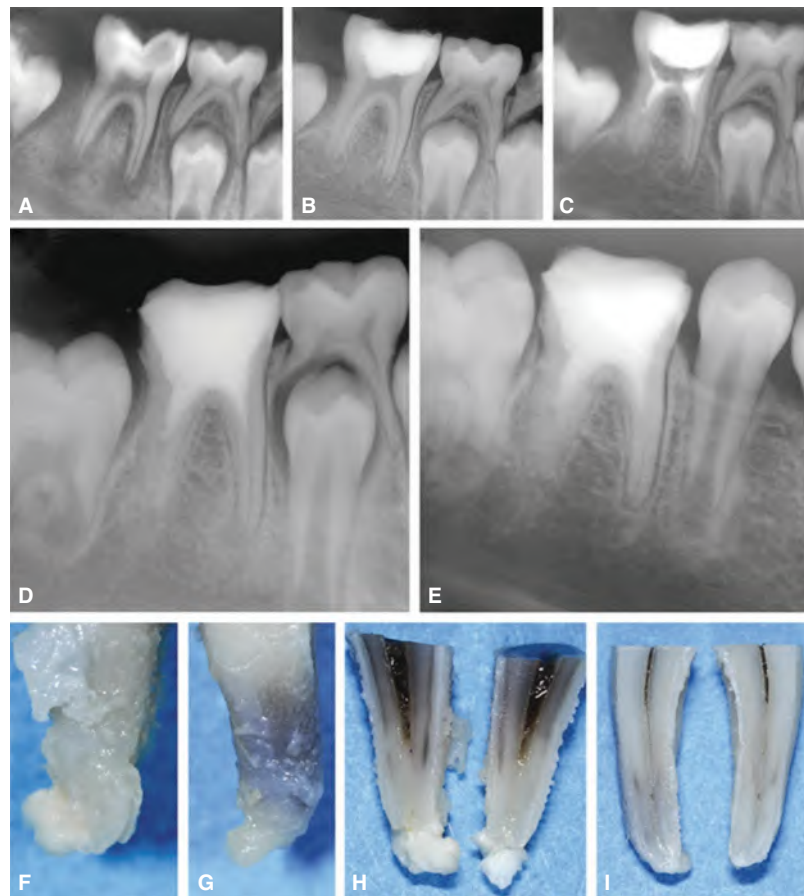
Mandibular first molar of a 9-year-old boy treated with a revascularization/revitalization procedure. A. Preoperative radiograph. B. Radiograph of the tooth taken five months after triple antibiotic treatment. C. Postoperative radiograph after revascularization/revitalization. D. 14-month follow-up radiograph. E. Radiograph taken after 25 months at the time of root fracture. F,G. Photographs of the distal and mesial roots after tooth extraction. H,I. Distal and mesial roots separated longitudinally into two portions. (Adapted with permission from Martin et al.²⁴²)
